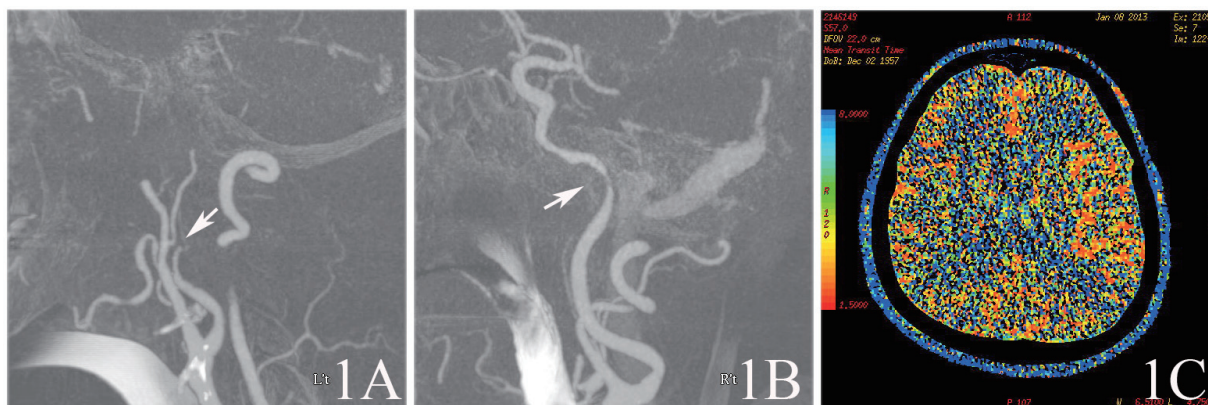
Pre-procedural computer tomography. Perfusion CT reveals left cervical ICA occlusion (arrow)(1A); Significant right internal carotid artery stenosis at petrous segment (arrow) (1B); Slightly prolonged mean transit time at right middle cerebral artery (MCA) territory (1C).
